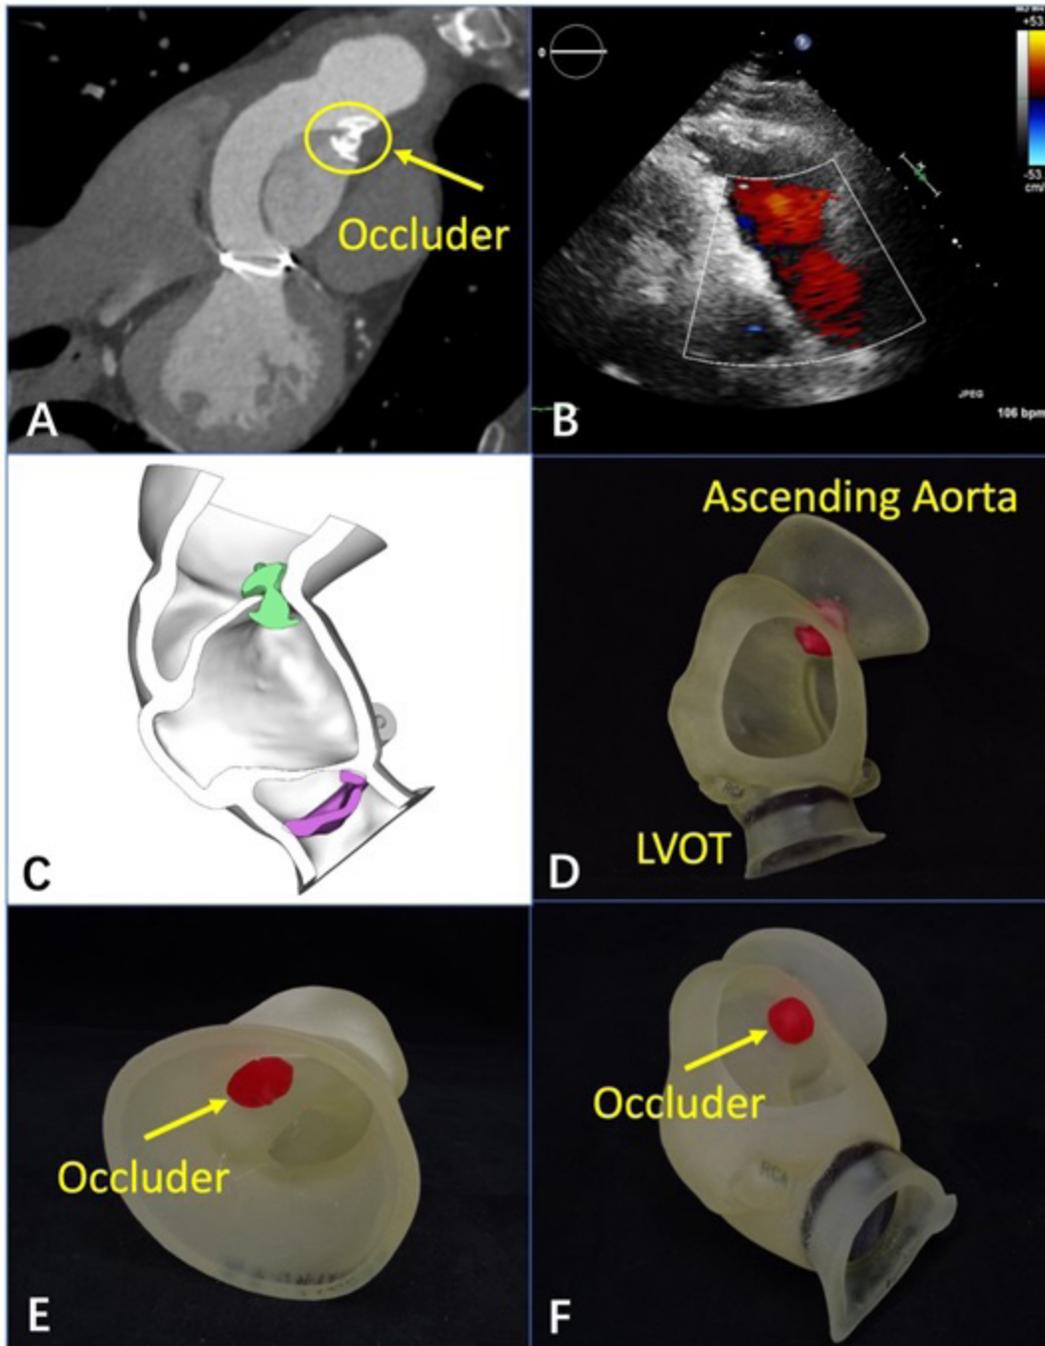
The 30-day follow-up images and the 3-dimensional printed model verified the position of the occluder located in the anastomotic leakage. (A-B) Transthoracic echocardiography and computed tomography angiography showed that the position and effect of the anastomotic leakage was ideal (arrow shows the occluder). (C) The 3-dimensional reconstructed model. (D-F) The 3D printed model (D. lateral view; E. Ascending aorta view; F. left ventricular view; Arrows show the occluder, and the red part is the printed occluder). LVOT: left ventricular outflow tract.
